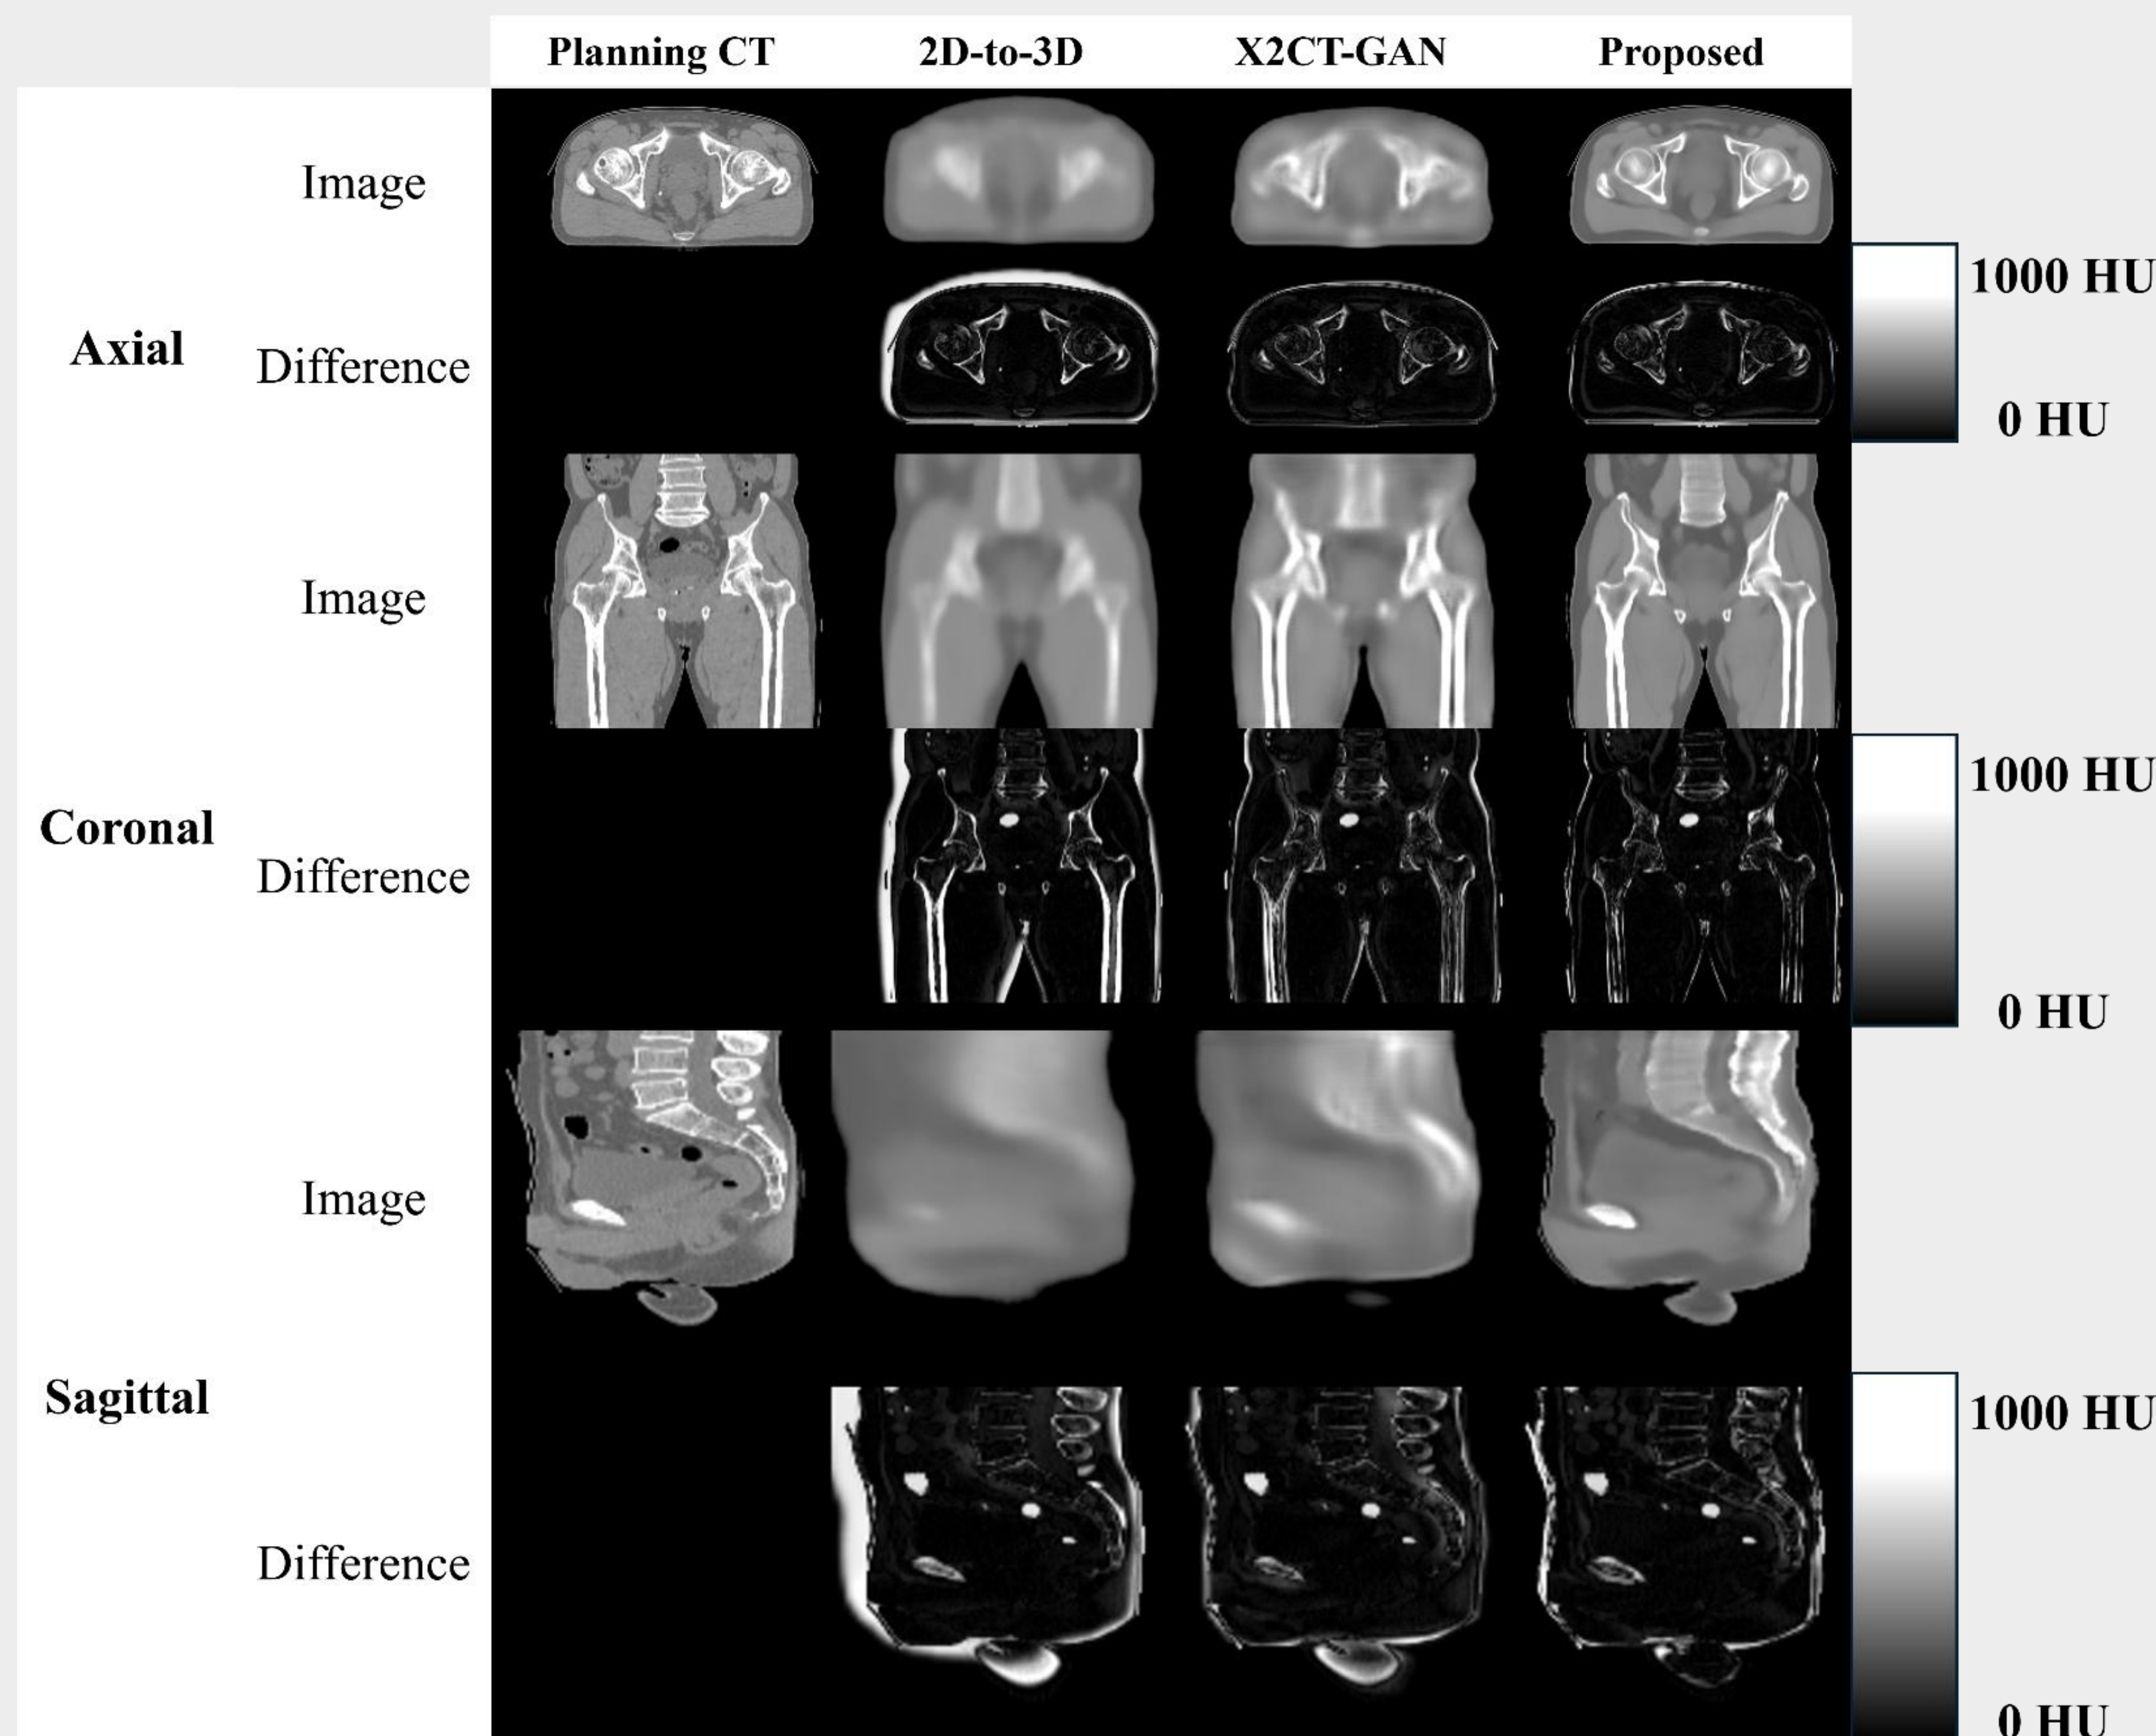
Planning CT, reconstructed sCT, and difference maps in three anatomical planes.
